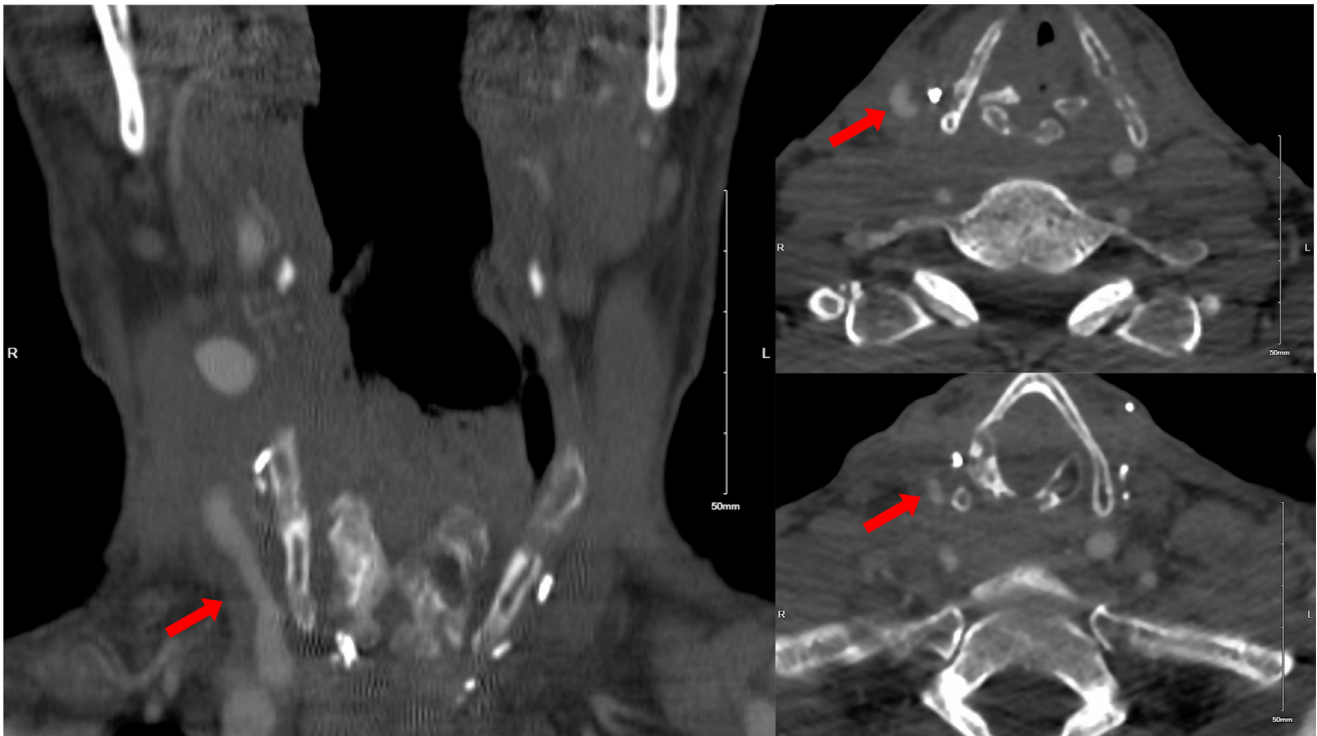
Coronal (left) and axial (right) CT scan of the neck with contrast showing right common carotid stenosis and pseudoaneurysm.
